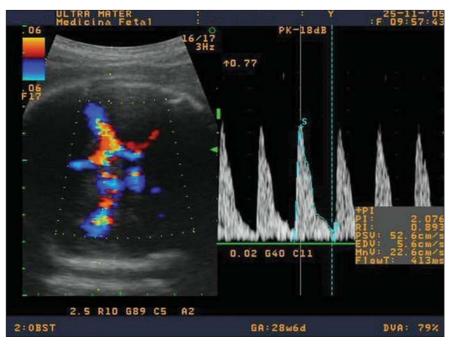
Doppler velocimetry of the cerebral artery visualized from the circle of Willis and insonated immediately after its origin in the internal carotid artery. The angle between the sound beam and the flow was captured as close as possible to 0°.
